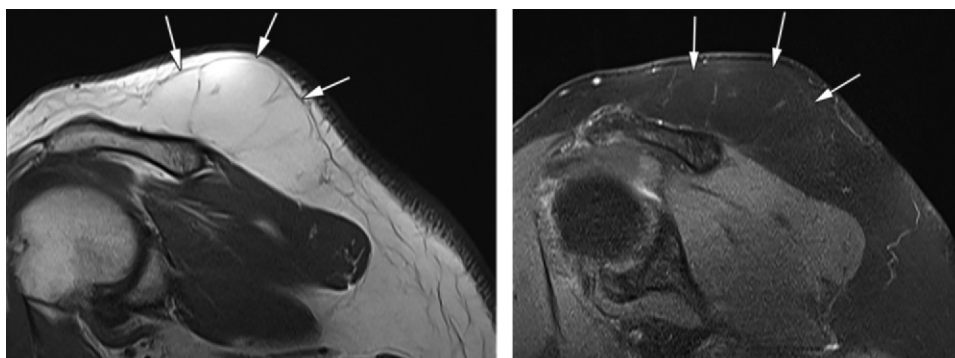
Superficial lipoma in a 53-year-old man with a left shoulder mass. (a) Oblique sagittal T1-weighted MR image of the shoulder shows a homogeneous fat-containing mass (arrows), which is similar in signal intensity to the adjacent subcutaneous fat. Note the presence of a thin capsule and thin (<2 mm) internal septa without a nonadipose component. (b) Postcontrast fat-saturated T1-weighted MR image in a similar imaging plane shows complete suppression of fat signal intensity within the mass (arrows), mild enhancement of thin internal septa, and no solid enhancing component.
